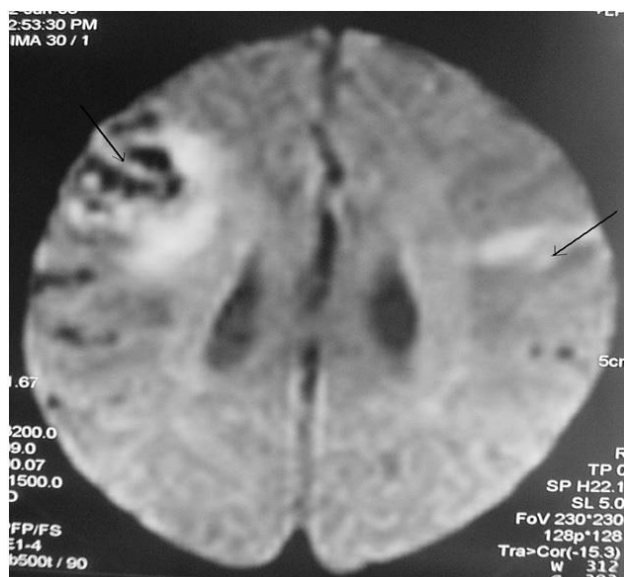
MRI of atrophied lesions in both rolandic opercula.
